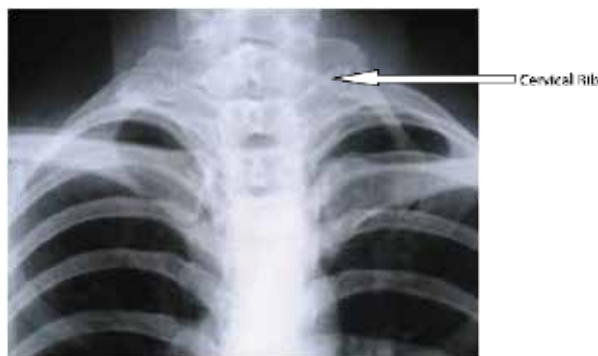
Frontal radiograph demonstrating cervical rib
